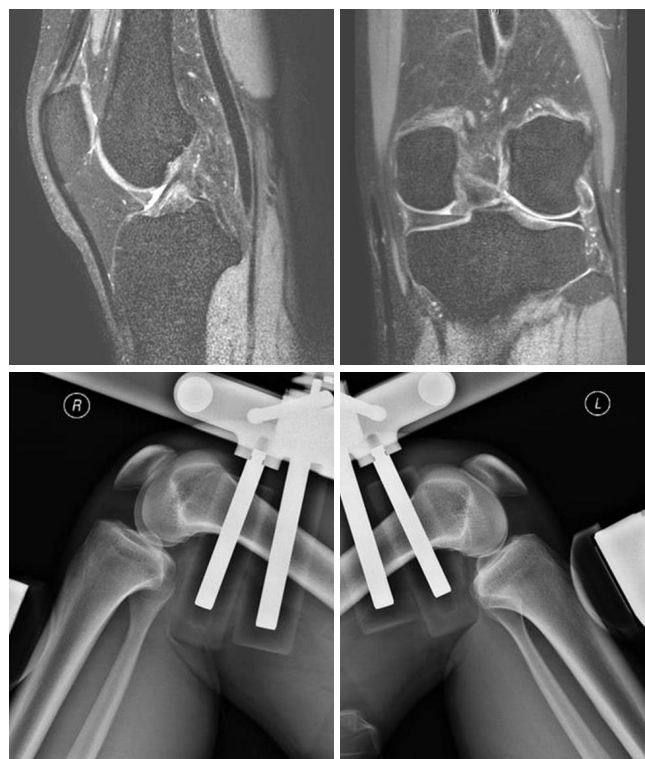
Preoperative MRI and Telos posterior stress radiography. The left knee of a 19-year-old male with popliteal pain and posterior instability of the joint due to a slip. Magnetic resonance image shows contour buckling, laxity, and increased signal in the posterior cruciate ligament. Posterior Telos stress radiographs indicate posterior instability of the left knee.
